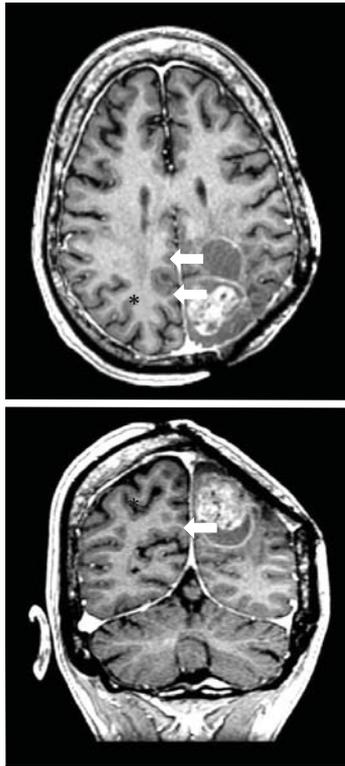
Gadolinium-enhanced MR imaging from 2021 of the recurrent astroblastoma from our patient. Evidence of 2 prior resections includes cystic cavities (arrows) into which the tumor is growing from the posterior medial aspect of the largest cavity. As with other cases of astroblastoma, there are bubbly features (asterisk) of recurrent enhancing tumor and minimal associated edema.
